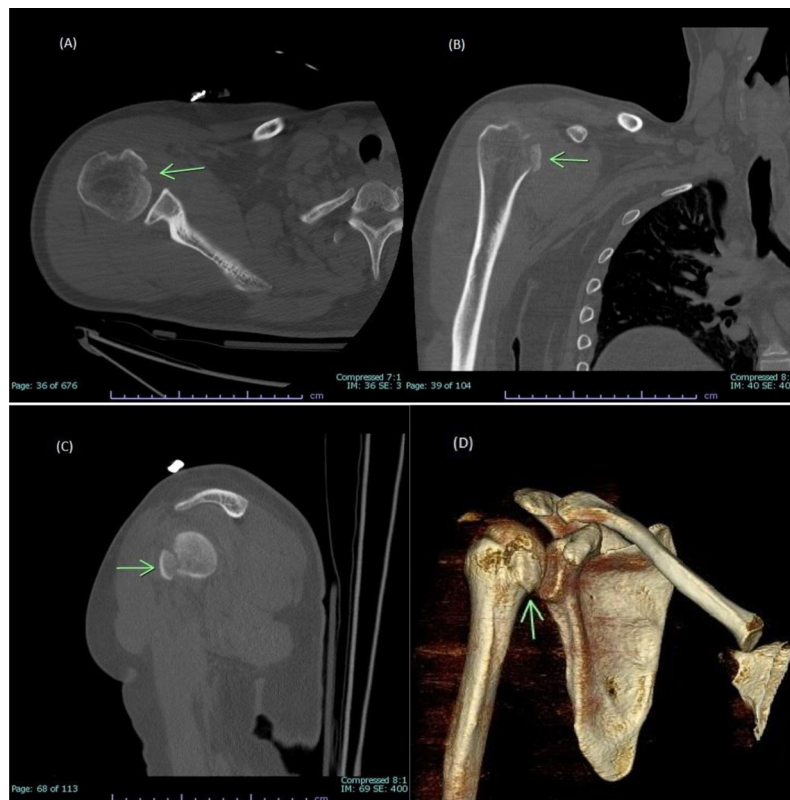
Right shoulder axial (A), coronal (B), sagittal (C), 3D volume-rendered (D) CT images showing an acute mildly displaced fracture of the lesser tuberosity.
